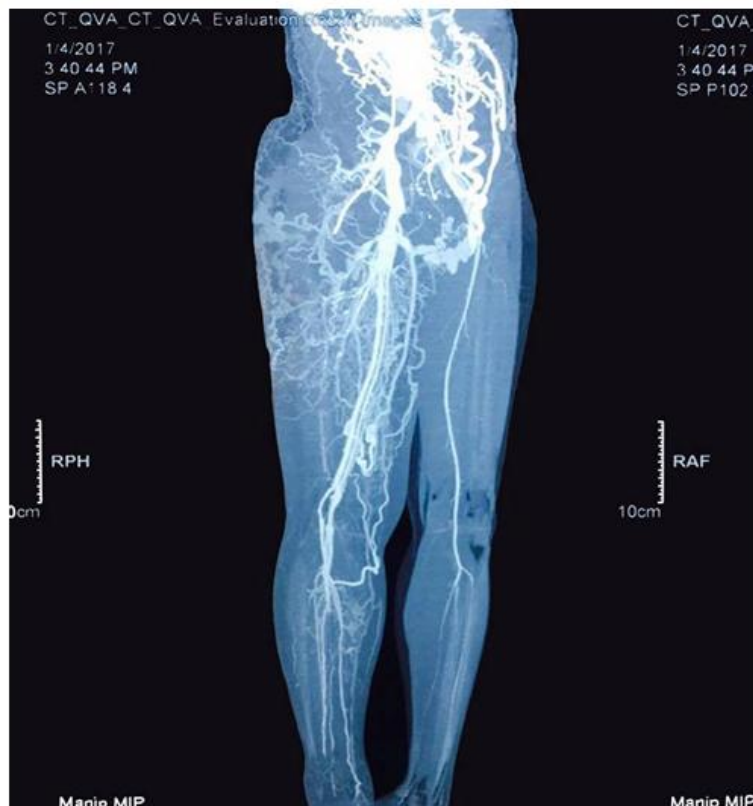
CT angiography figure
